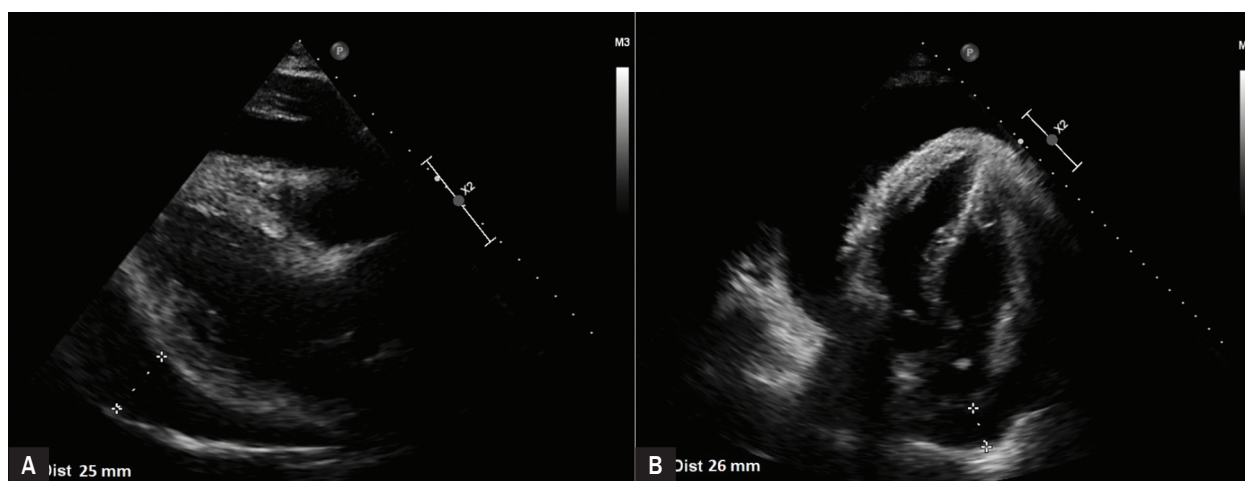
Transthoracic echocardiography prior to pericardiocentesis: pericardial effusion at right ventricle 15 mm, posterior wall of left ventricle (LV) 25 mm, lateral wall of LV 27 mm, right atrium 26 mm: A. Long axis view; B. Four chamber apical view
